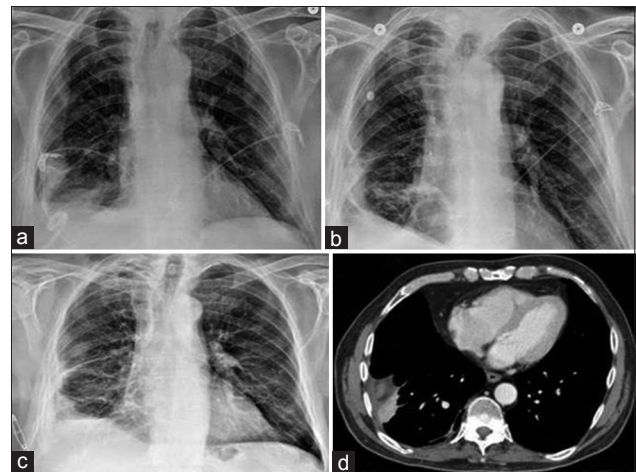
Sequential radiographs demonstrating gradual resolution of empyema. A pigtail is visible in the right empyema cavity (a). The pigtail has been replaced by a surgical chest tube in anticipation of discharge with an empyema tube (b). The chest tube has been converted into an empyema tube (c) and a clip has been placed over the chest tube to prevent the accidental retraction of the tube into the pleural space. The empyema cavity has resolved and the empyema tube has been removed (d). A small pleural scar has replaced the empyema cavity
